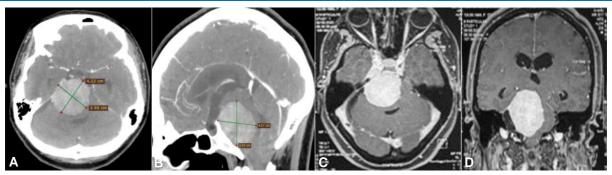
(A and B) Brain tomography with contrast in (A) axial section and (B) sagittal section, showing a large petroclival tumor (4.22 x 3.90 x 3.83 cm). (C and D) Brain MRI with contrast in (C) axial section and (D) sagittal section showing petroclival tumor that compresses and displaces the brainstem and cerebellum
